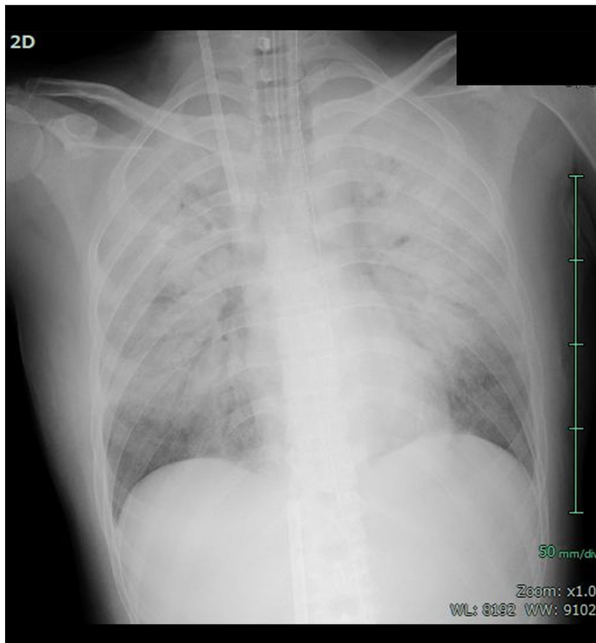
Chest X-ray examination on arrival. The chest X-ray revealed that severe bilateral infiltrative shadows reflecting severe hypoxemia, acute respiratory distress syndrome, and multiple organ dysfunction.
